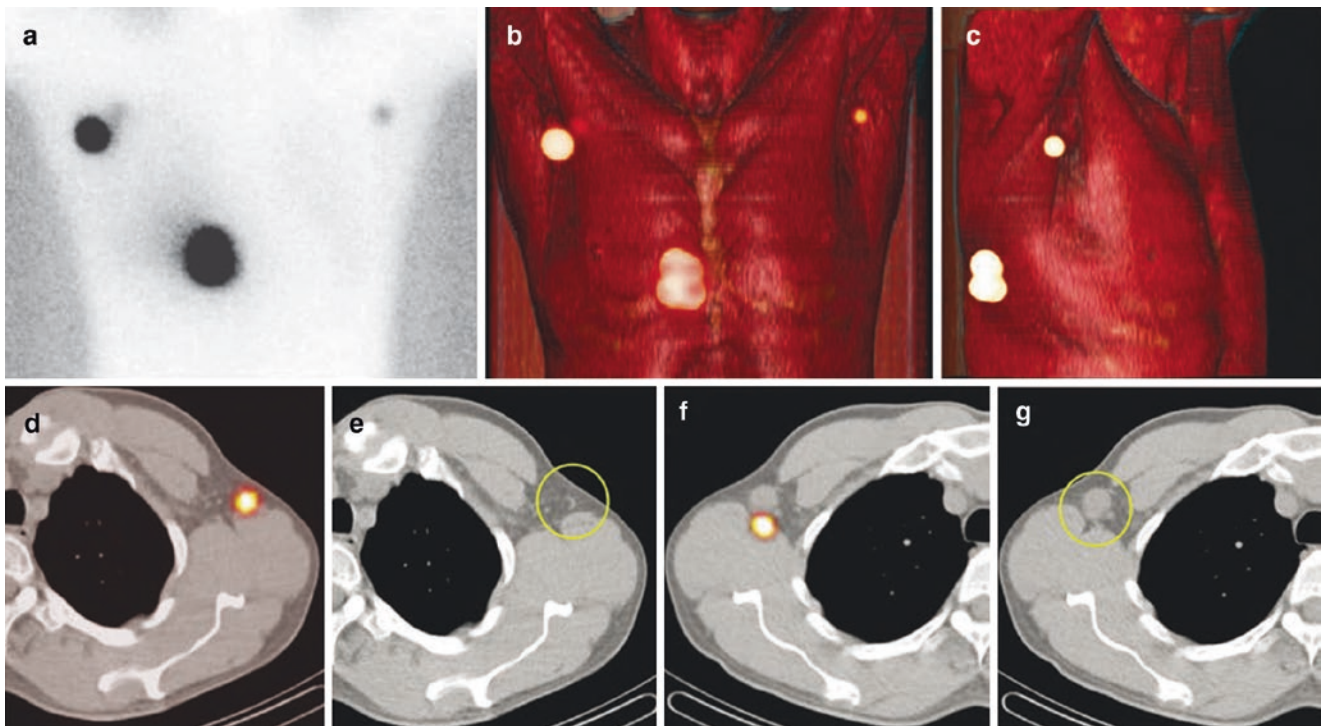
Upper panels: (a) planar anterior view acquired in a patient with melanoma located in the back of the right torso, showing lymphatic drainage to both axillae, as better demonstrated by SPECT/CT with volume rendering for 3D display, respectively, in the anterior and in the right oblique view (b and c). Lower panels: fused axial SPECT/CT section at two different levels, showing the location of radioactive lymph nodes, respectively, in the left axilla (d) and in the right axilla (f).
